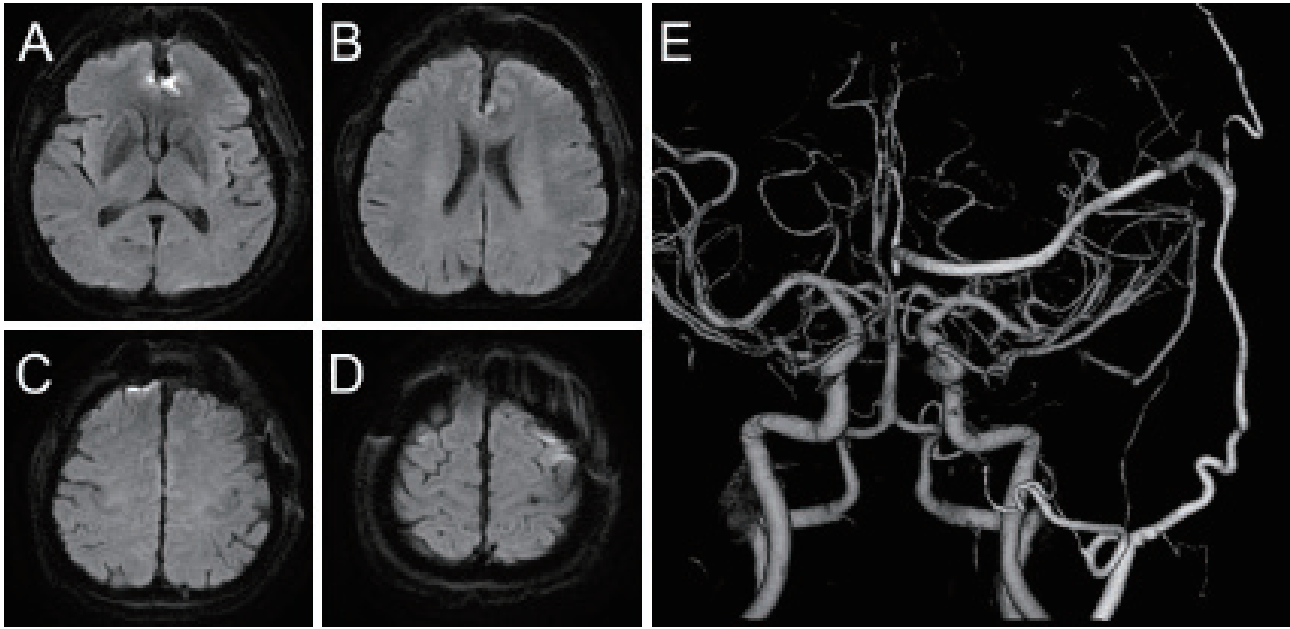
Postoperative MRI scans.
